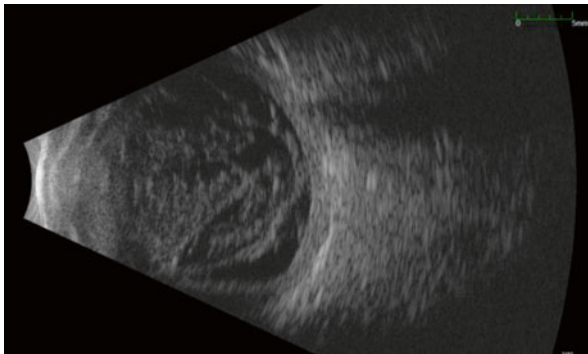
B-scan ultrasonography showing vitreous opacities in an eye with post-traumatic endophthalmitis
